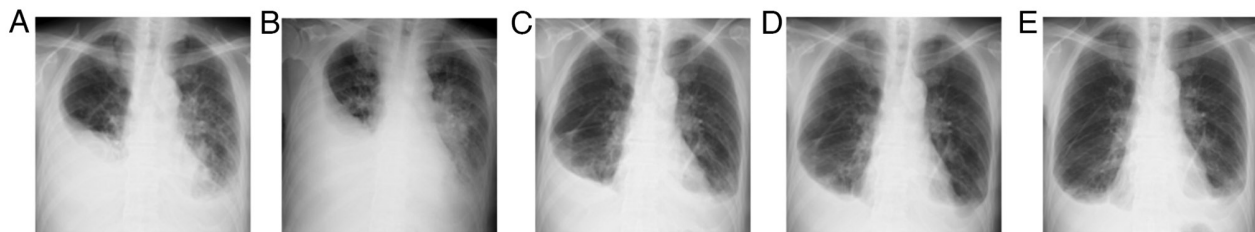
Chest radiographs (A) before starting anti-tuberculosis drugs, (B) before starting prednisolone and at (C) 3, (D) 4 and (E) 6 weeks after starting prednisolone.
